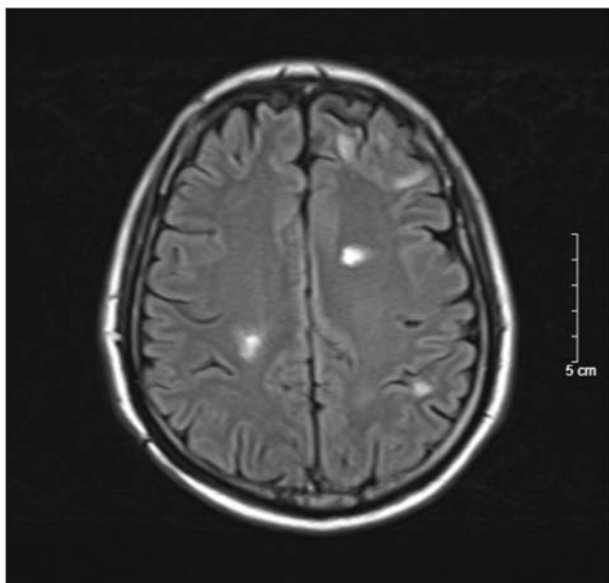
Cranial MRI magnetic resonance image in September 2022 exhibits no sign of cerebral edema.
